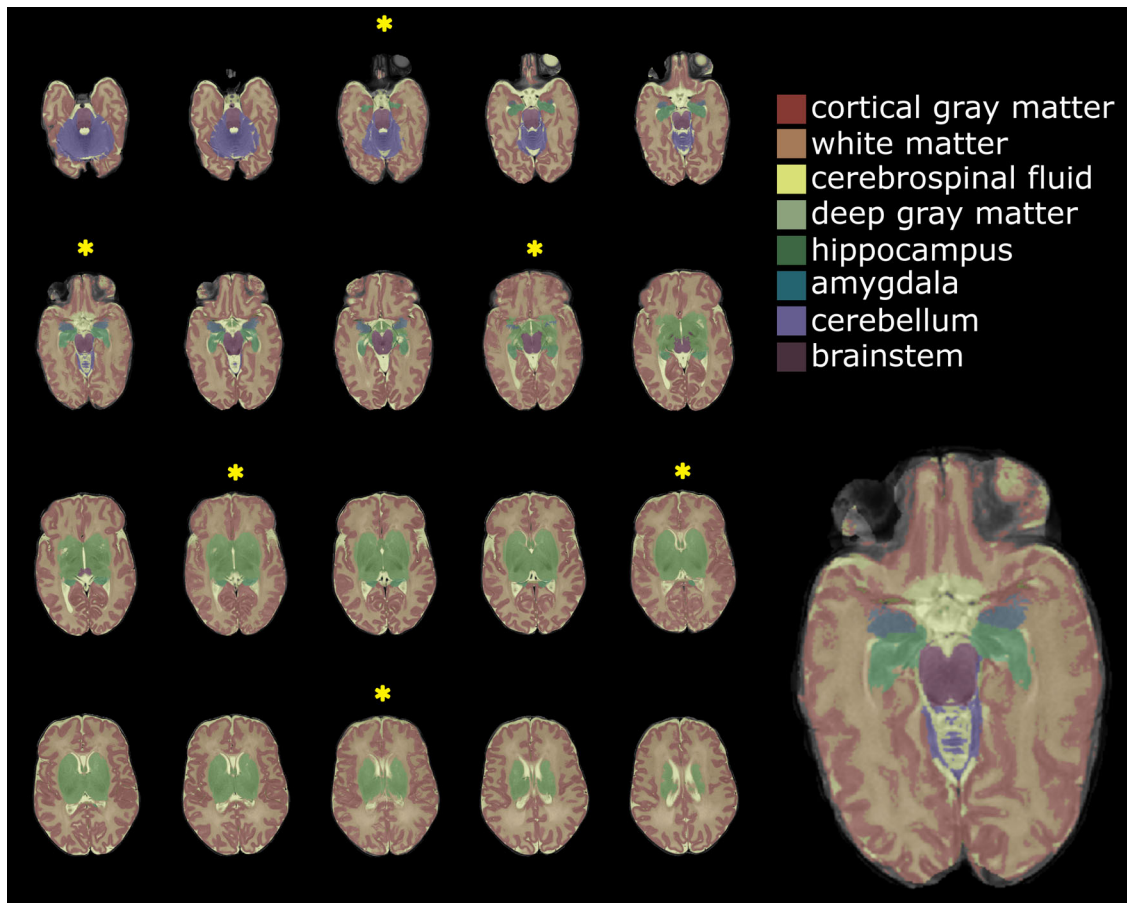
Automatically segmented T2-weighted MRI scan (number of packages 3; late preterm infant, gestational age  $35^{+2}$  weeks, postmenstrual age at scan  $40^{+1}$  weeks) with motion artifacts. Slices with motion artifacts are marked with a yellow asterisk and an enlarged example is shown on the right
